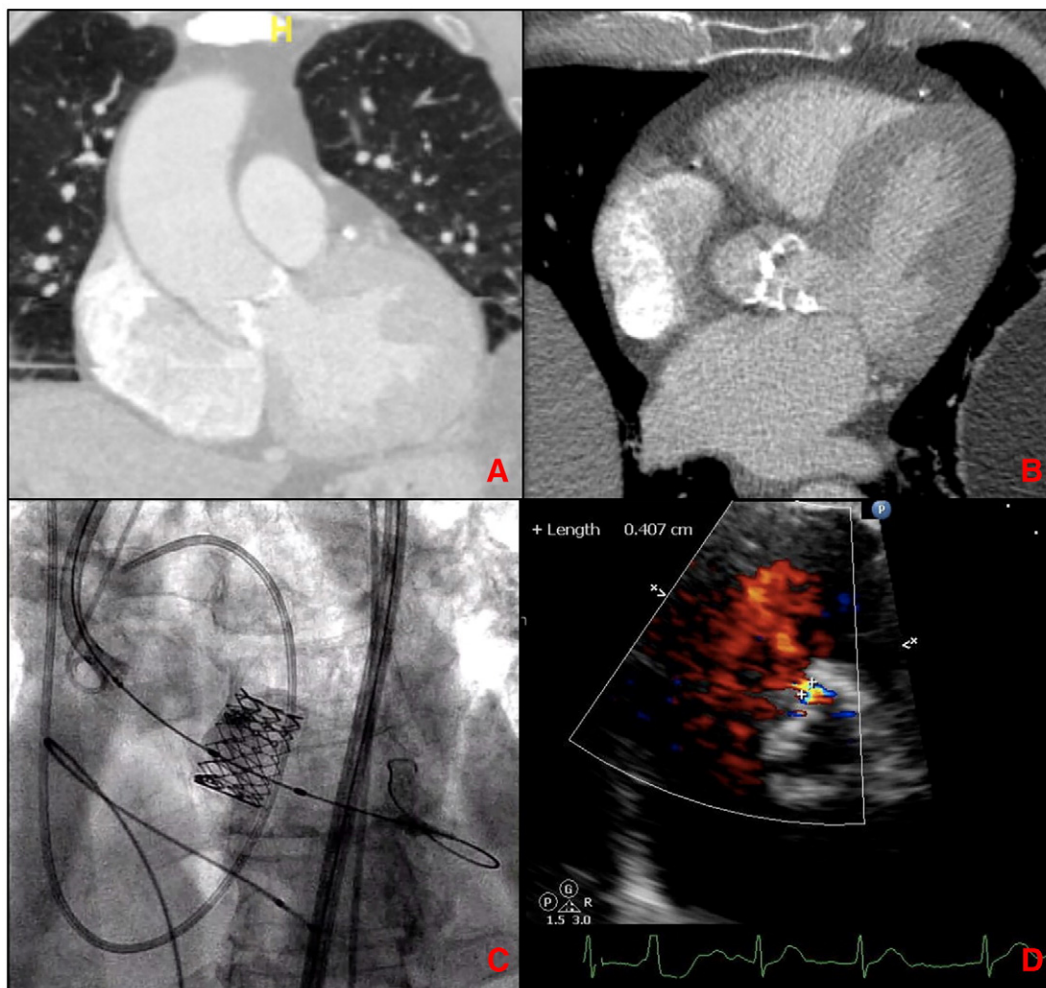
(A, B) CT scan showing minimal LVOT calcification. (C) Transfemoral deployment of 29 mm Edwards Sapien XT valve. (D) Transthoracic echocardiogram with parasternal short-axis view at the base showing 4 mm membranous ventricular septal defect with left to right shunt. (Abbreviations: LVOT = left ventricular outflow tract).
